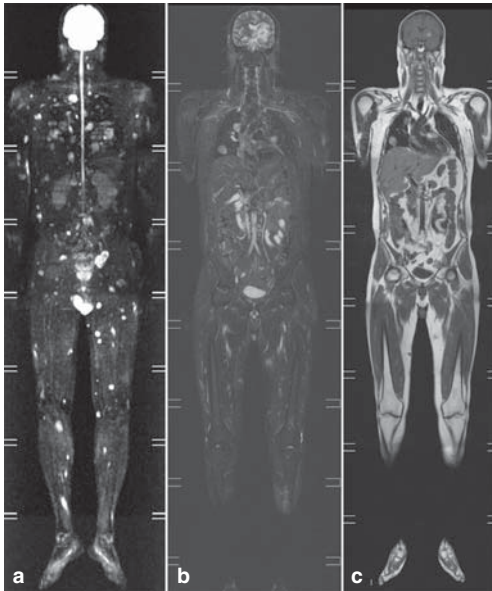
A 41-year-old man with malignant melanoma and widespread metastases including the brain. WB MRI imaging shows multiple lesions outside the field of view of CT thorax and abdomen. (a) A maximum intensity projection (MIP) image of DWI shows the disease distribution in a valuable overview of the entire body; (b) coronal T2-STIR and (c) coronal T1W sequence, respectively, show further anatomical details of metastatic lesions.
